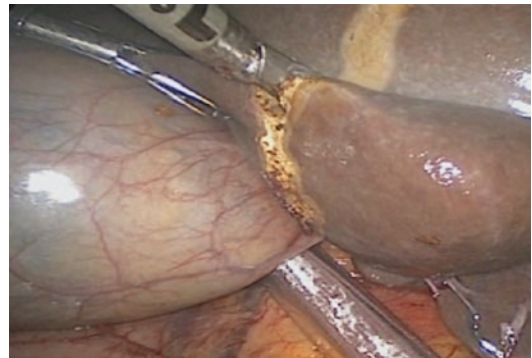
Following USS guided marking of the surface of the liver superficial parenchymal dissection is performed using an ultrasonic dissector
